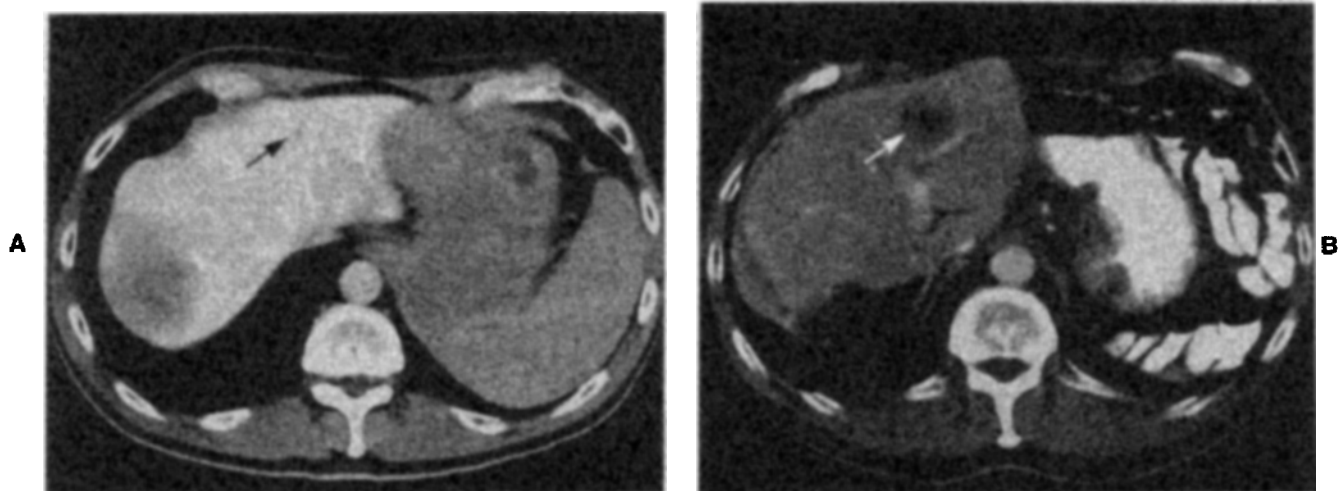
A, Preoperative CTAP scan showing a lesion in the medial segment that was classified as a cyst at IOUS examination. B, Subsequent CT scan 14 months later showing progression at the disputed site (arrow).
